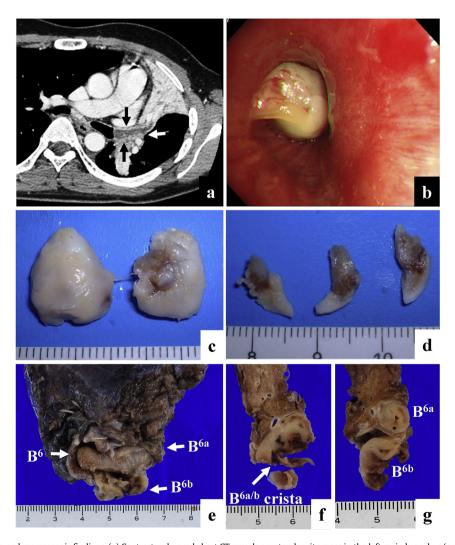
Radiological, endoscopic, and macroscopic findings. (a) Contrast-enhanced chest CT reveals a water density mass in the left main bronchus (arrows). (b) Bronchoscopy shows a white polypoid mass filling the left main bronchial lumen. (c, d) The tip of the endobronchial tumor partially resected by endoscopic snaring procedure. The surface of the tumor is smooth, and the cut-surface is tan in color. (e–g) Formalin-fixed bronchopulmonary tissue obtained by left lower lobe segmental resection. A cylindrical mass arises from the superior segmental B^{6a/b} crista and enlarged the lumen of B⁶, B^{6a}, and B^{6b}.
